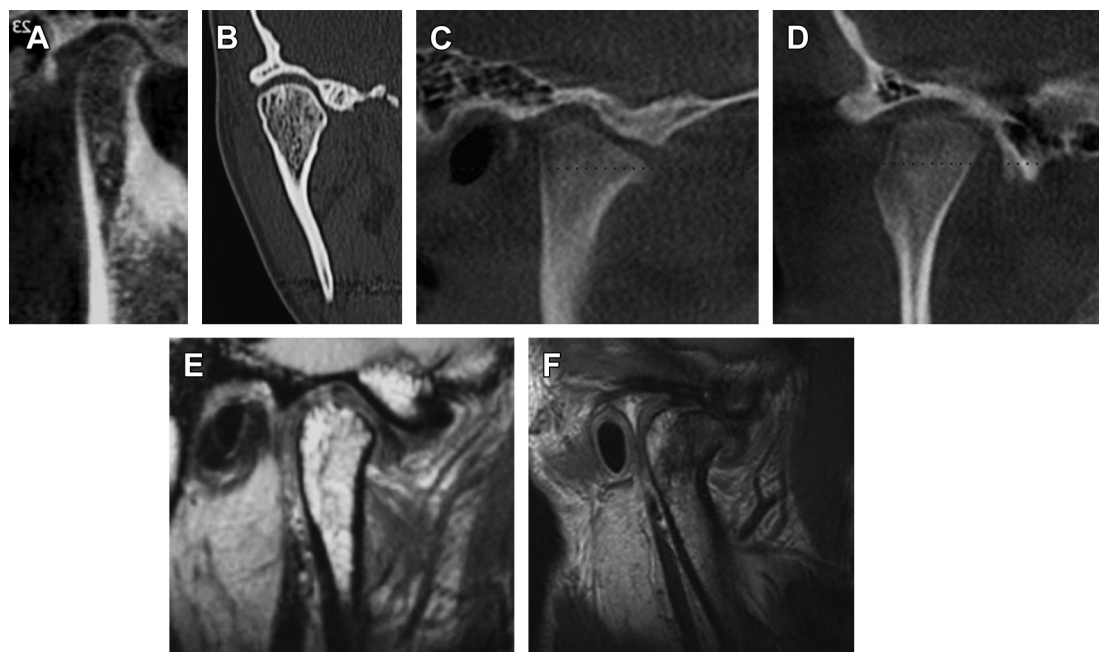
At CT scan, (A) CH type 2A shows a larger condyle with increased vertical height of the condylar head and neck. (B) In the coronal view, the crown of the condyle may be more rounded than a normal condyle, (C, D) condylar hyperplasia type 2B have exophytic growths extending from the condylar head. At MRI, (E) the CH type 2A, and (F) CH type 2B, even with large exophytic growth development, the articular disc will commonly be in place.
